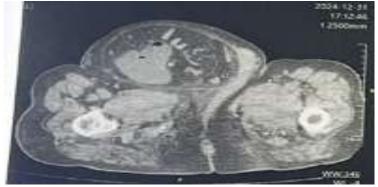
CT scan of the hernia sac containing the cecum and small intestine.
